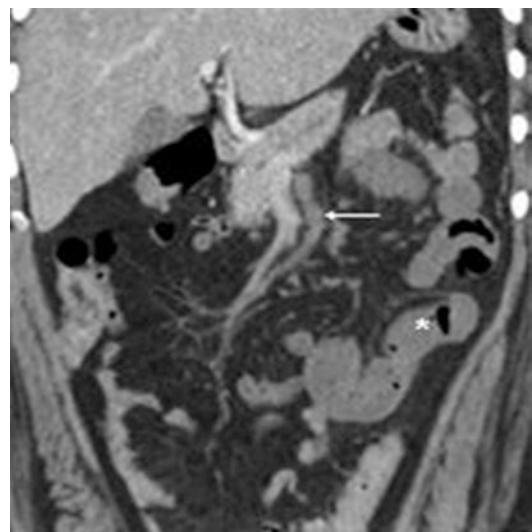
Bowel ischemia on a portal venous phase coronal abdominal CT image in a 56-year-old man. Absent small bowel perfusion is demonstrated by hypoenhancing and mildly dilated small bowel loops in the left abdomen (asterisk), which are ischemic due to an occluded superior mesenteric artery (arrow)
